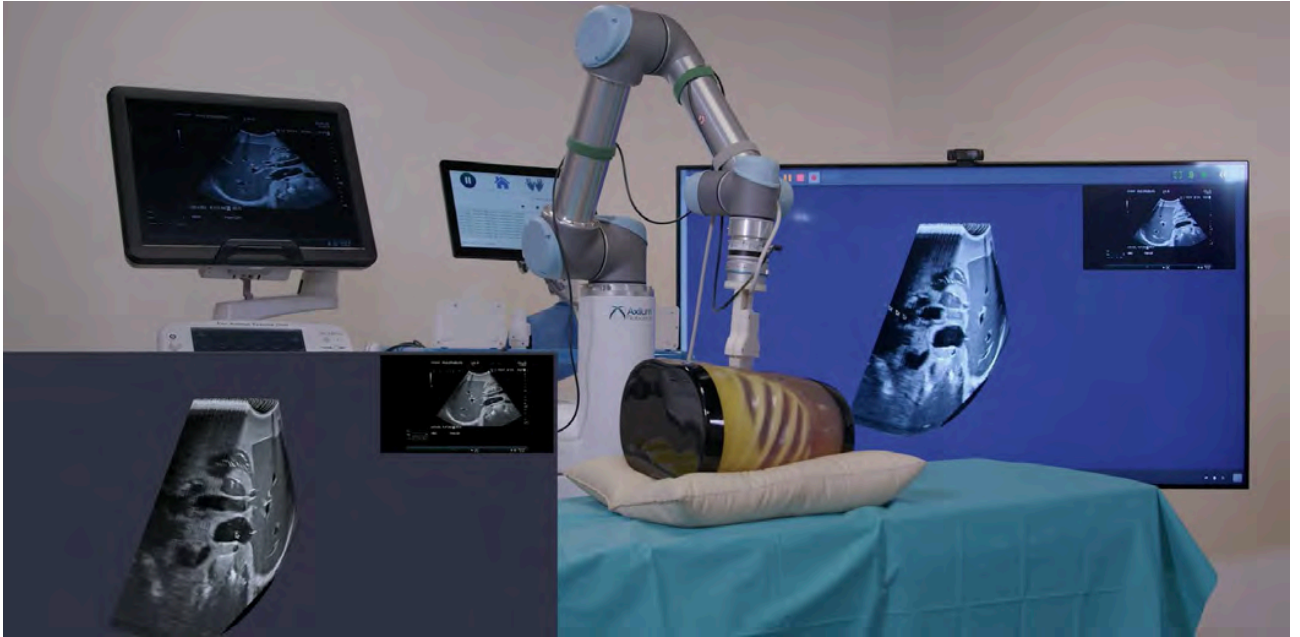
Artificial intelligence station for automated ultrasound diagnosis
